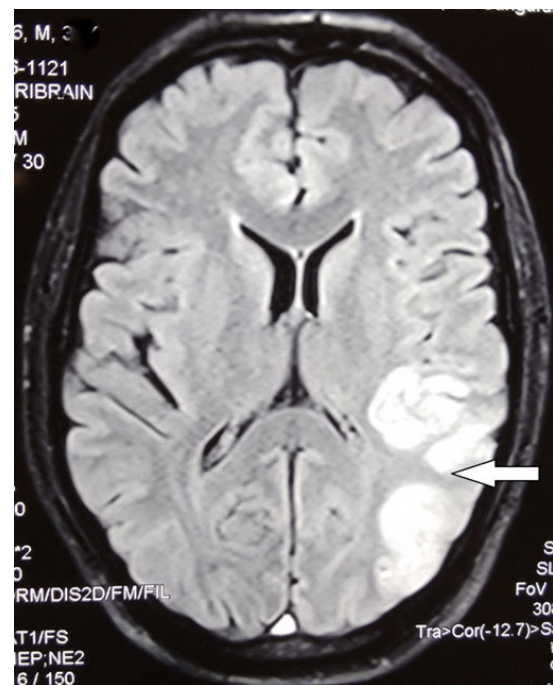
Contrast MRI brain, T1-weighted image: left sided fronto-temporo-parietal and occipital infarct. Arrow shows large venous infarct in left parieto-occipital region. MRI: magnetic resonance imaging
